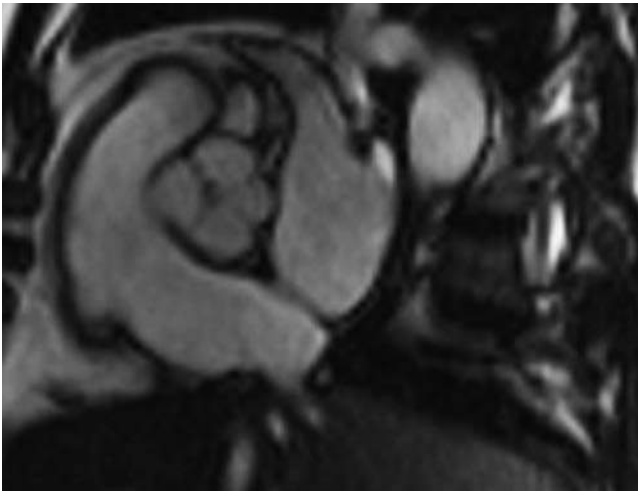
Magnetic resonance image of the rare quadricuspid aortic valve (short-axis view). (Courtesy Dr. N. Johnston.)
